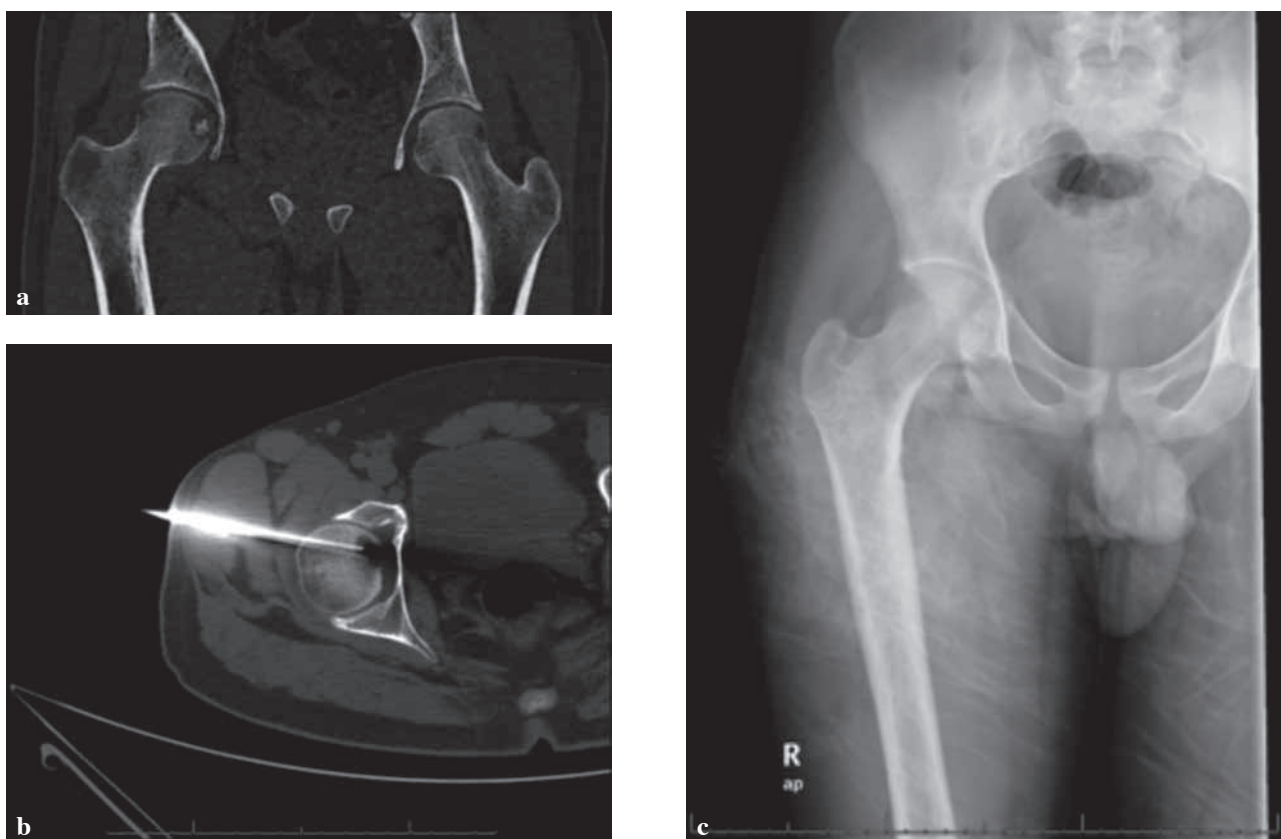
a. CT image of the lesion ; b. CT guided localization of the tumor ; c. Postoperative X ray
